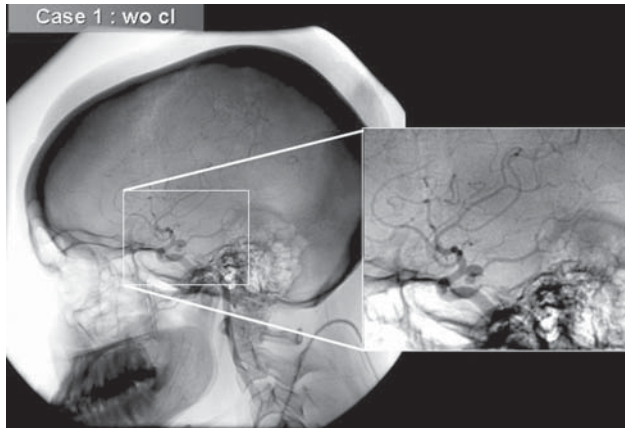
A 53 year-old woman presented with abrupt onset of headache and intractable pain. CT revealed subarachnoid hemorrhage. A diagnostic 3D rotational DSA showed a lobulated aneurysm located in the supraclinoid ICA
